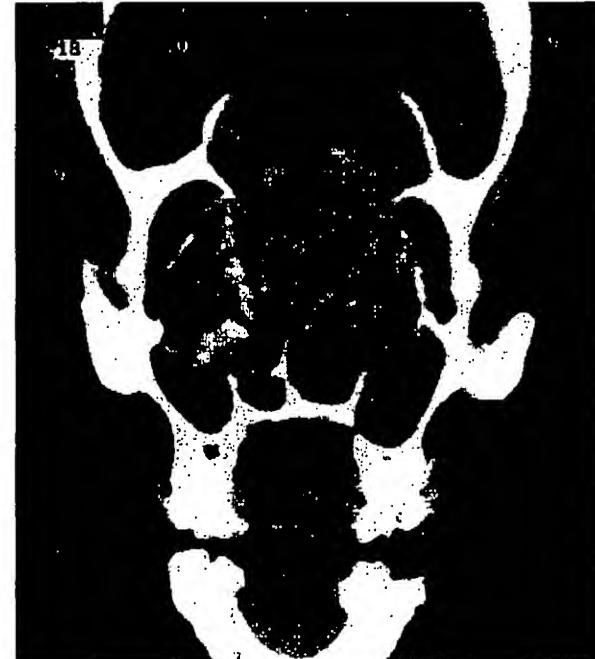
Coronal CT demonstrates expansion of allergic fungal sinusitis into the orbits and anterior cranial fossa. Despite the massive encroachment noted on this CT scan, no fungal invasion of tissue was present.
